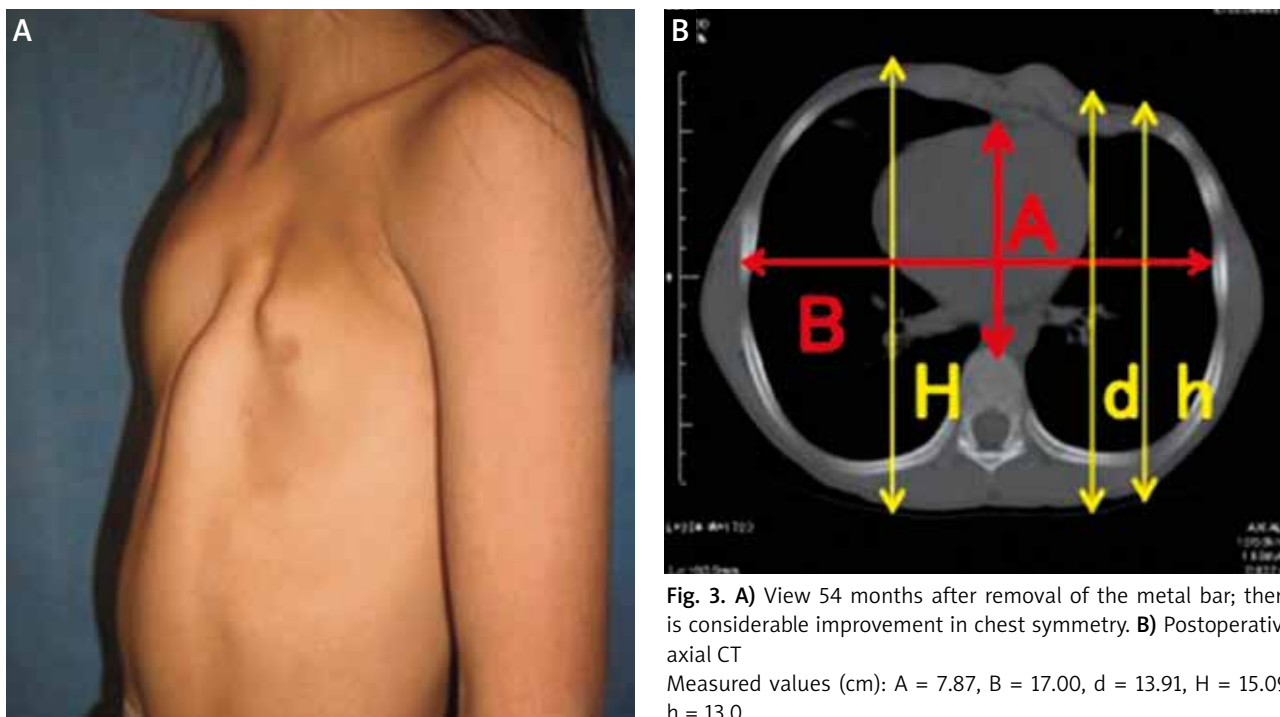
A) View 54 months after removal of the metal bar; there is considerable improvement in chest symmetry. B) Postoperative axial CT
